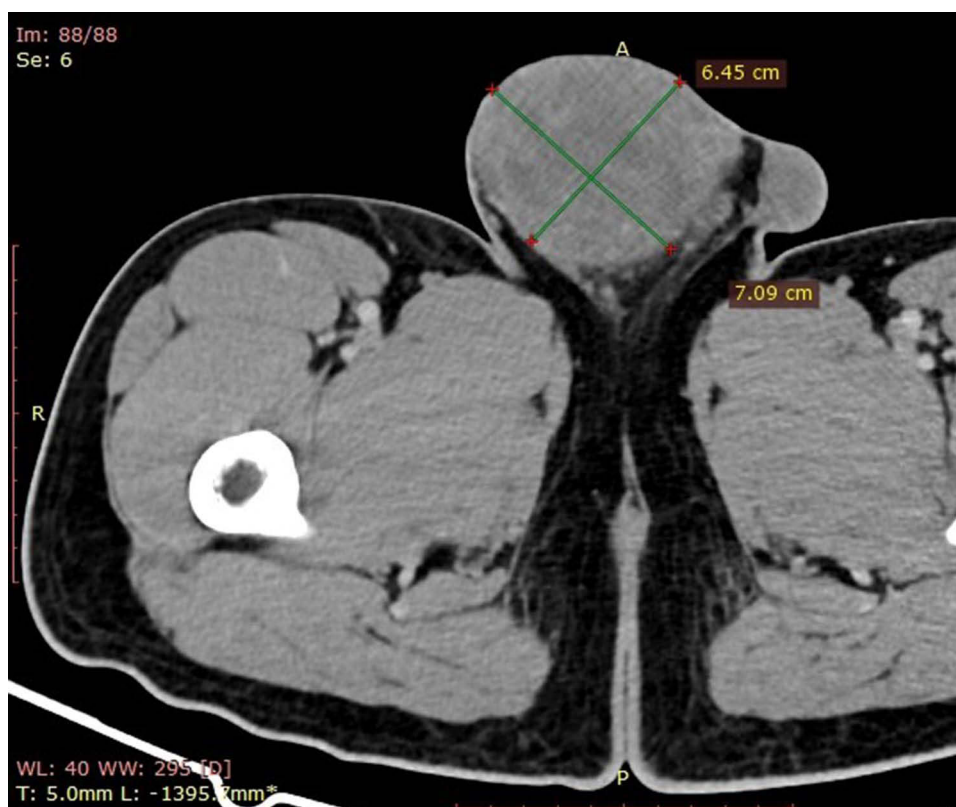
Axial contrast-enhanced CT of the pelvis demonstrates a markedly enlarged right testis almost entirely replaced by a heterogeneously enhancing solid mass measuring approximately 7.1×6.5 cm (longest axes), in keeping with a primary malignant intratesticular neoplasm. (R: Right, P: posterior).
